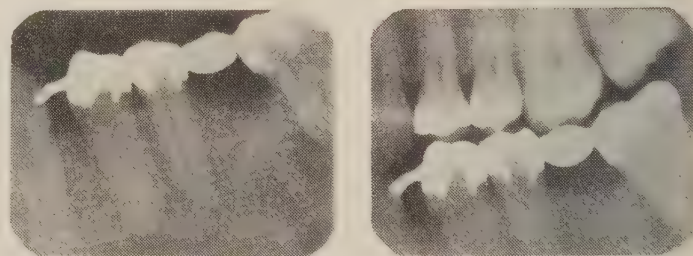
Radiographs taken in February 1966.
